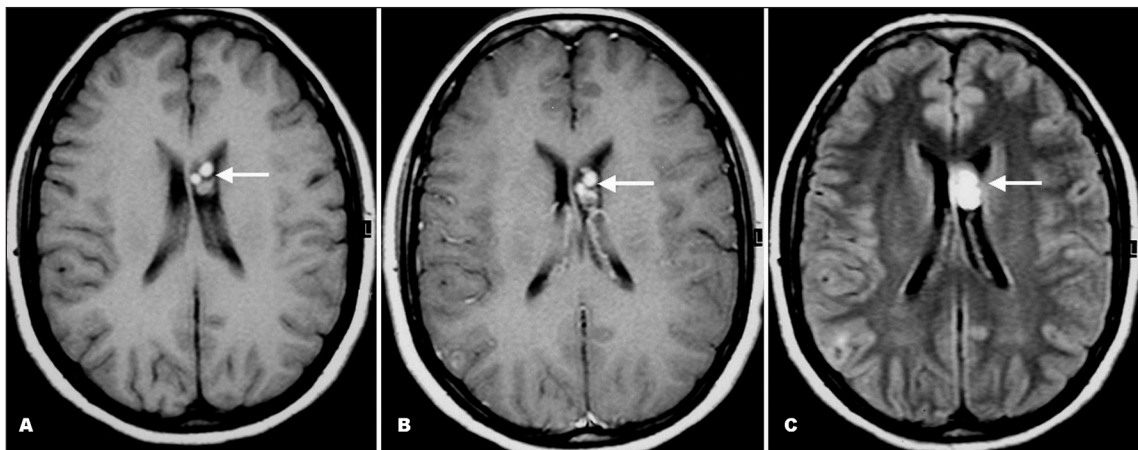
Axial T1-weighted pre- (A) and post-gadolinium (B) and FLAIR (C) MR images demonstrate multiple well-defined round lesions in the frontal horn of the left lateral ventricle, with high signal on both sequences, and with no significant enhancement after contrast administration (arrows).
